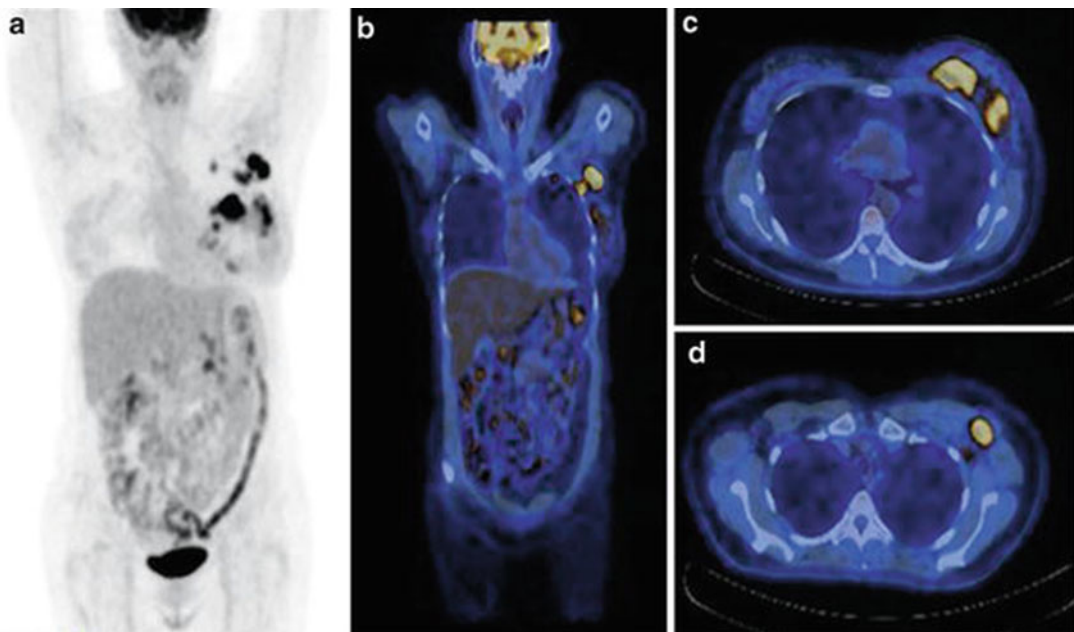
Baseline whole body [^{18}F]FDG PET/CT in patient with locally advanced TNBC (a, maximum intensity projection). Fused PET/CT images show multifocal [^{18}F]
